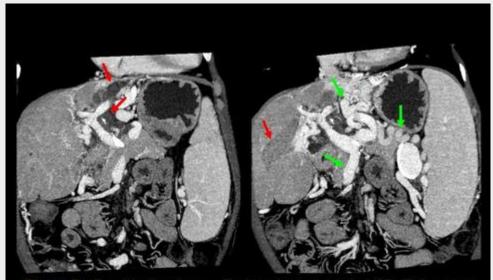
Caroli's Syndrome. Post-contrast abdominal CT. Reformated oblique MIP images depicting the dilated intra-hepatic bile ducts, some of which filled with calculi (\Longrightarrow). Note the splenomegaly and the tortuosity and dilation of the portal, splenic and perigastric veins (\Longrightarrow) due to portal hypertension.
